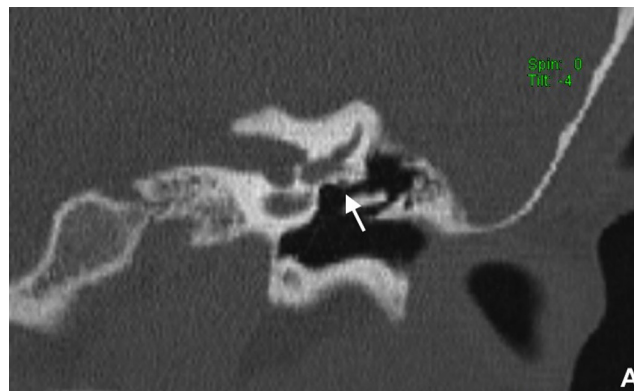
Left coronal computed tomography showing the normal location of the facial nerve which is located superior and lateral to the oval window (White arrow).
